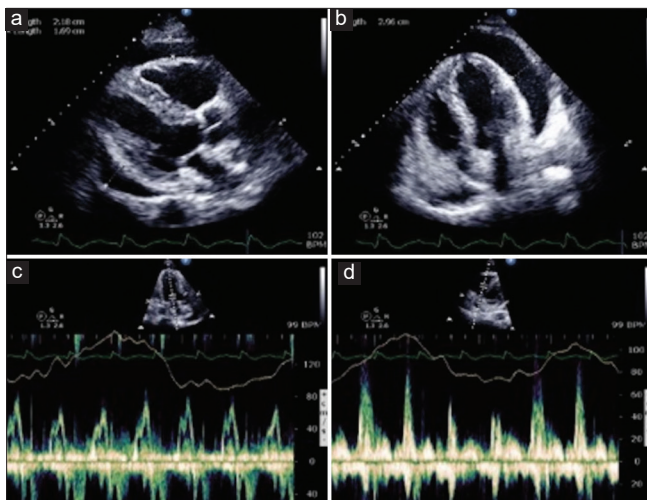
Echocardiograms before pericardiocentesis show (a & b) circumferential pericardial effusion measuring up to 2.96 cm, (c) respiratory variation of diastolic mitral inflow, and (d) respiratory variation of diastolic tricuspid inflow.
